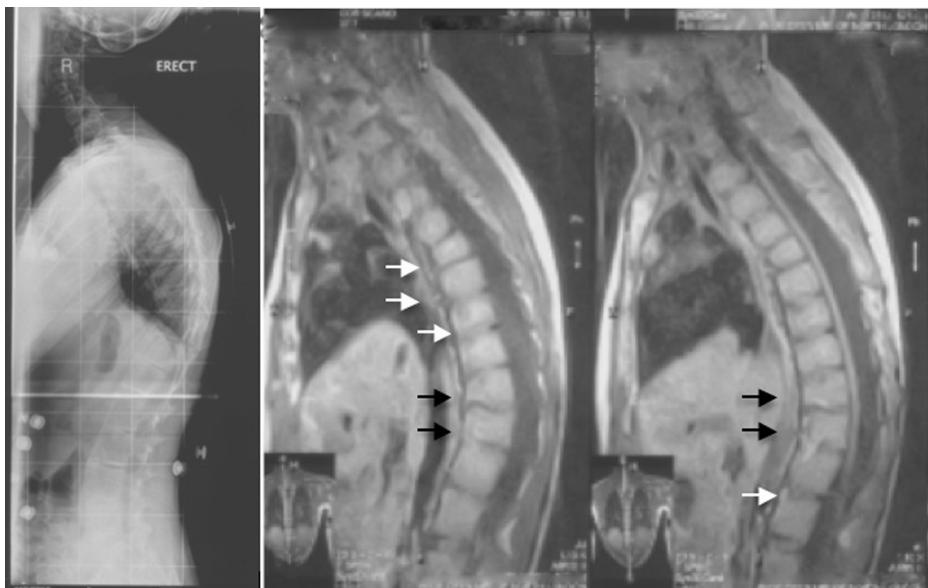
(Left) Lateral whole spine radiograph at 12 years of age during brace treatment, showing anterior fusion at multiple levels. (Right) Sagittal T1 magnetic resonance imaging of the thoracolumbar spine. There is a solid fusion at the anterior disc at T10–T11 and T11–T12 (black arrows) and multilevel anterior disc space obliteration (white arrows). The discovertebral anterior corner signal intensity changes at the anterior fused bars likely represent fatty marrow changes.
